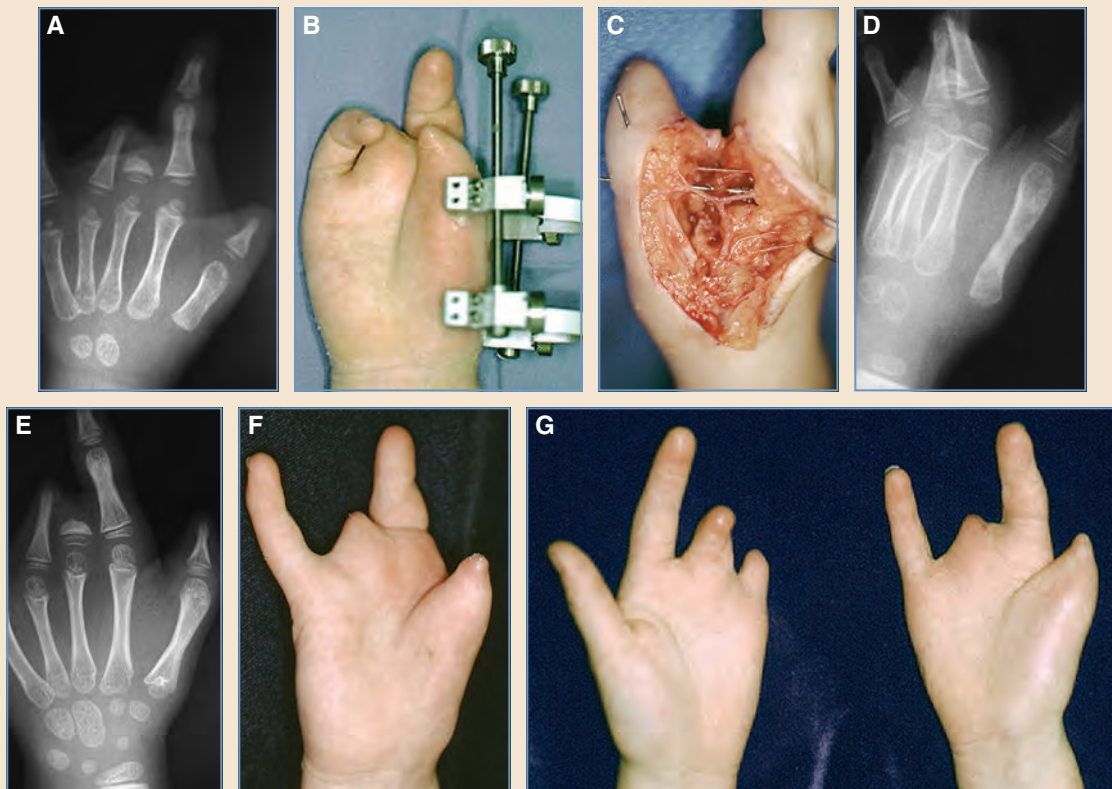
Constriction ring syndrome treated with distraction lengthening. A, Radiograph of a young girl with a congenital amputation at the thumb interphalangeal joint level with a tight first web space. Note the tapered appearance of the proximal phalanx. B, A distraction apparatus is pulling each end of the metacarpal away from the osteotomy site at the middle diaphyseal level. One clockwise turn of the screw equaled a 1.0 mm gain. C, The new bone regenerate (*callostasis*) advances toward the midportion of the gap created. The stretching injury to soft tissue is impressive. All vessels, nerves, and tendons are intact. D, The thumb metacarpal is now as long as the index. E, Five years later, both metacarpals are growing, but the index is now longer. F, The first web space was deepened to increase thumb mobility and increase its span. G, Although shorter than normal, this thumb has functioned very well on her dominant hand.
